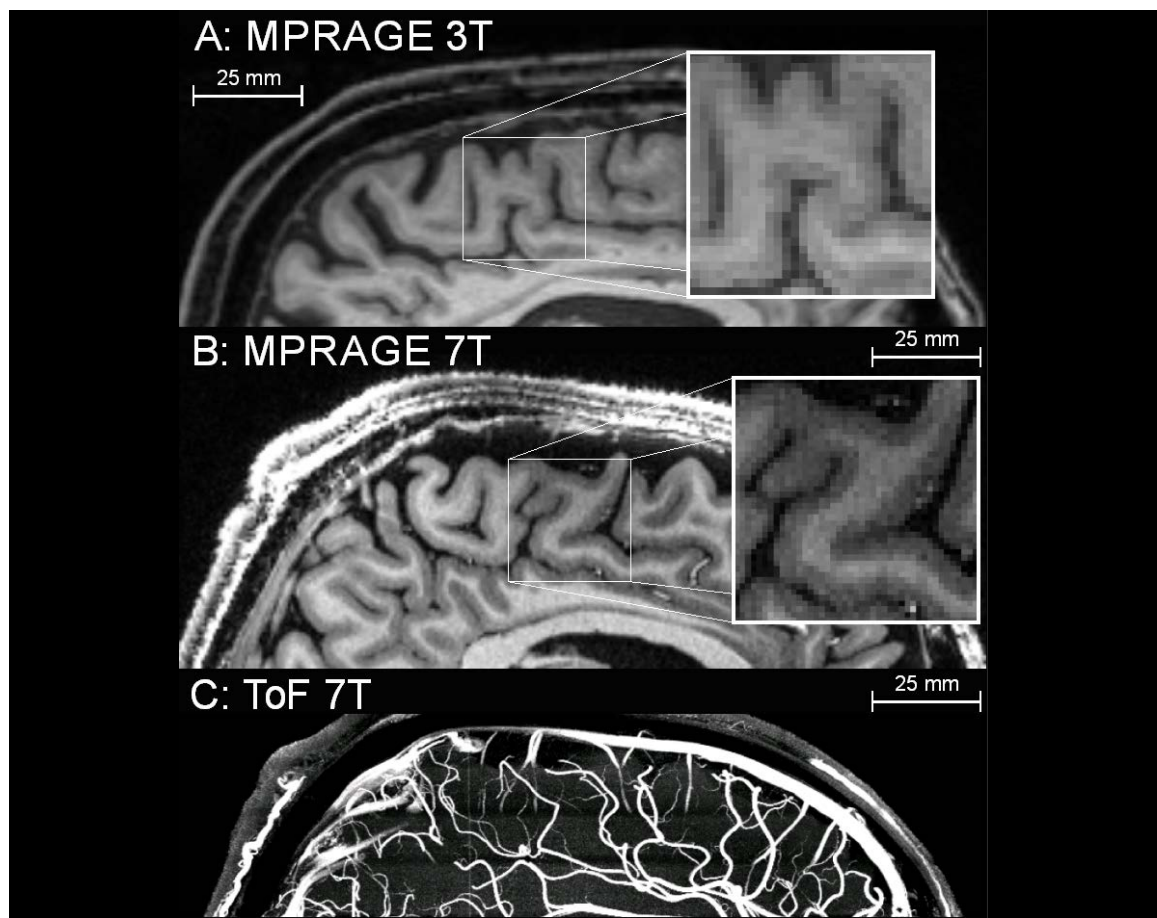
Comparison between structural MPRAGE sequences taken with 3T MRI (in A: resolution $1 \times 1 \times 1$ mm³) and high-resolution MRI with prospective motion correction at 7T (in B: resolution $0.7 \times 0.7 \times 0.7$ mm³). Note the highly improved contrast between gray and white matter, as well as the visibility of larger vessels in the MPRAGE sequences. High resolution ToF MRA (C) taken at 7T with prospective motion correction at a resolution of $0.25 \times 0.25 \times 0.25$ mm³.
